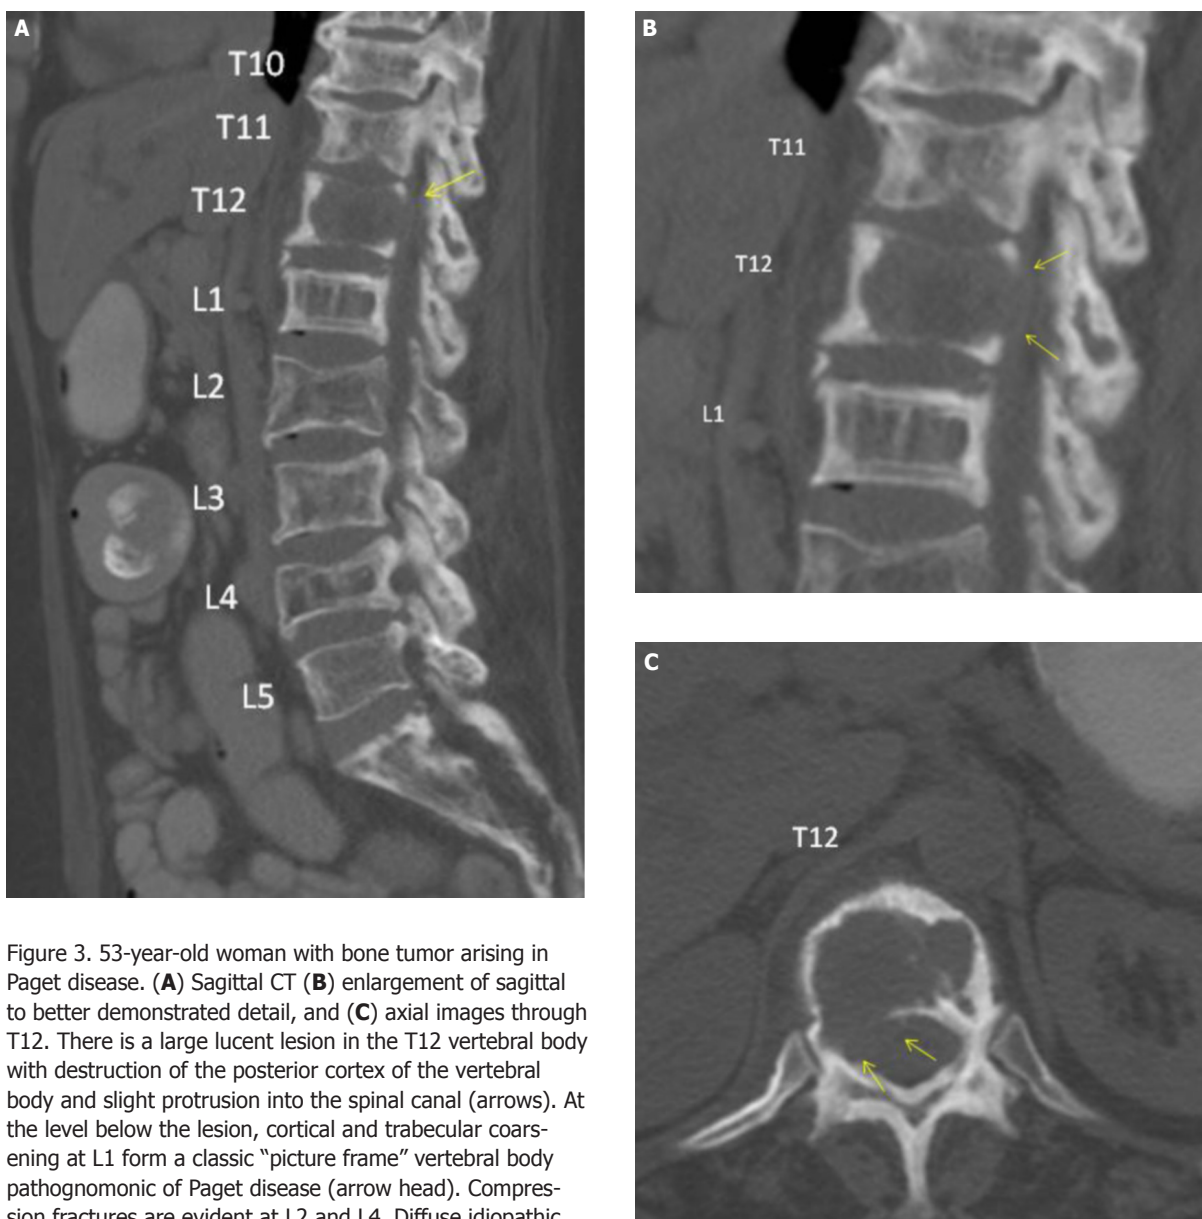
53-year-old woman with bone tumor arising in Paget disease. (A) Sagittal CT (B) enlargement of sagittal to better demonstrated detail, and (C) axial images through T12. There is a large lucent lesion in the T12 vertebral body with destruction of the posterior cortex of the vertebral body and slight protrusion into the spinal canal (arrows). At the level below the lesion, cortical and trabecular coarsening at L1 form a classic “picture frame” vertebral body pathognomonic of Paget disease (arrow head). Compression fractures are evident at L2 and L4. Diffuse idiopathic skeletal hyperostosis (DISH) is present from T8-11.
